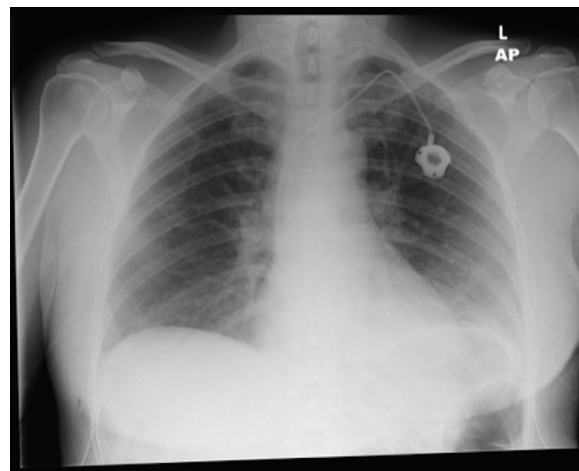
Chest radiograph performed on day one post-operatively showing mild left basal atelectasis. Drains are in place with a small area of right-sided surgical emphysema. A left Port-A-Cath is in situ from the patient's pre-operative chemotherapy. No additional chest imaging has been performed.
